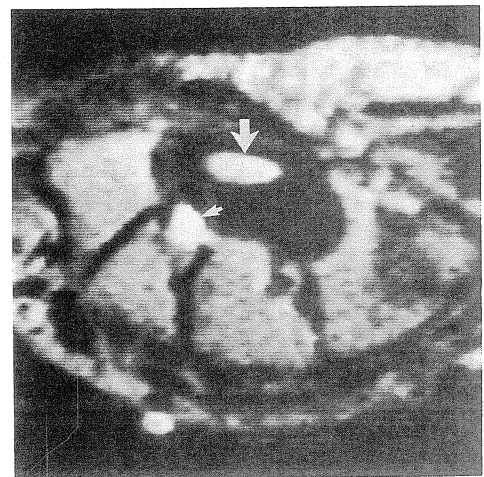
23-year-old woman with carpal tunnel syndrome. Axial T2-weighted (2400/90) MR image of right wrist at hook of hamate bone shows enlarged median nerve (large arrow) with increased signal intensity. Note high-signal-intensity ganglionic cyst (small arrow).
